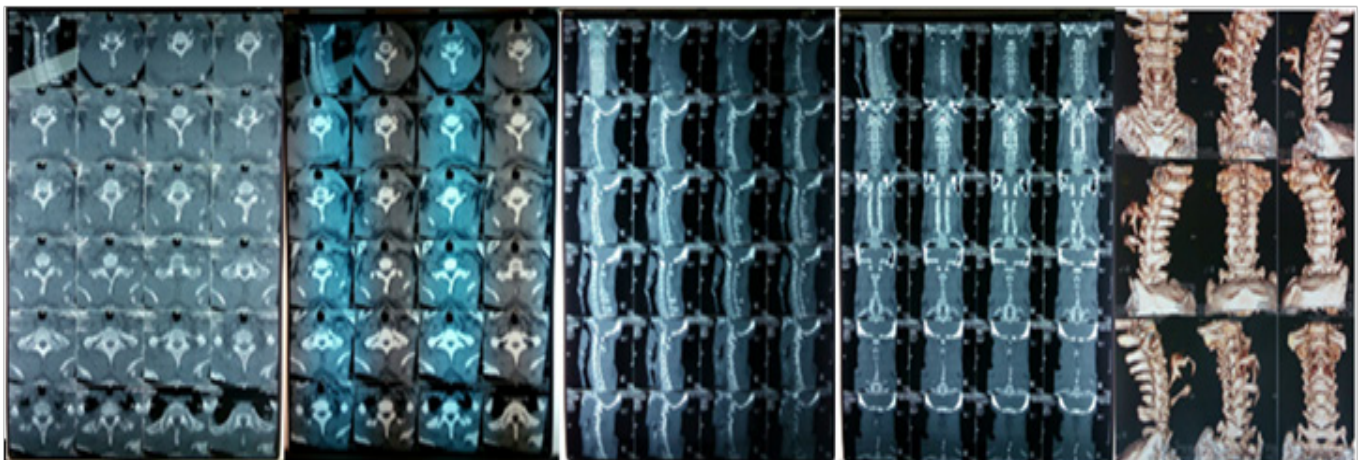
CT scan image of cervical spine
